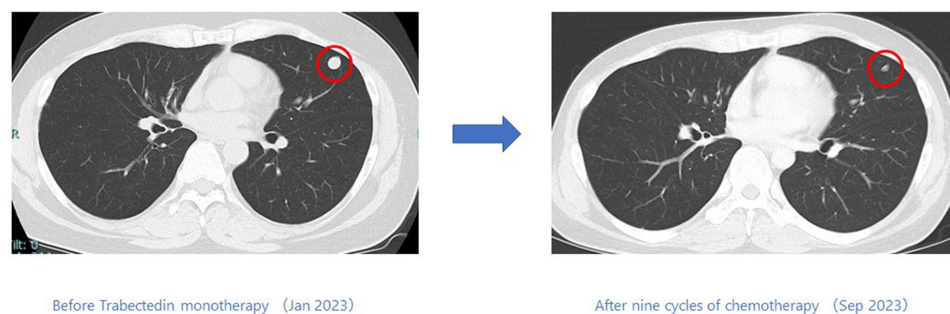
Changes in imaging of Case I patient before and after trabectedin administration (Chest CT) The pulmonary metastasis showed a significant reduction after nine cycles of trabectedin monotherapy compared to the findings of pre-treatment.
